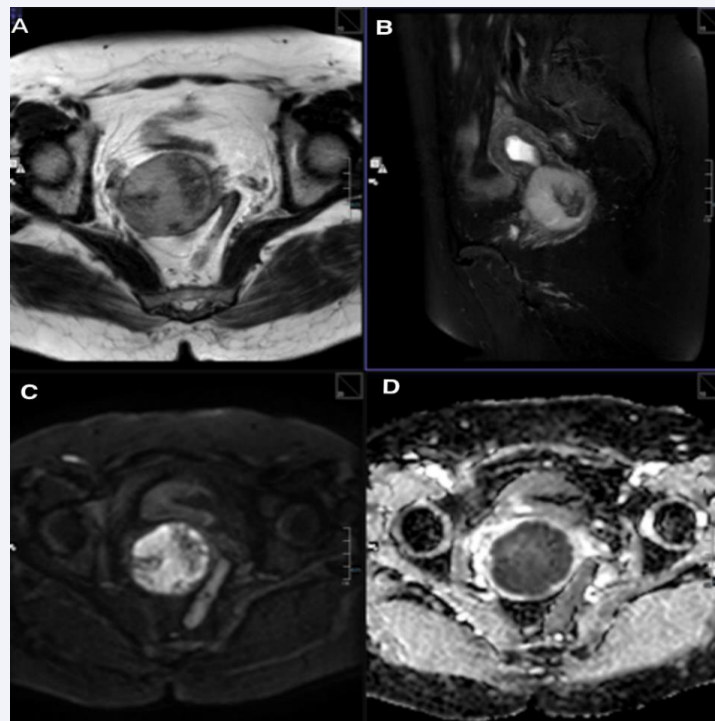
MRI shows lesion in the uterus. (A) T2W1 showed high signal lesion visible in the cervix. (B) fat suppresses the sequence showed cervical high signal lesion with uneven signal and clear boundary with the surrounding area. (C) DWI showed high signal lesion visible in the cervix. (D) ADC showed low signal lesion visible in the cervix.
